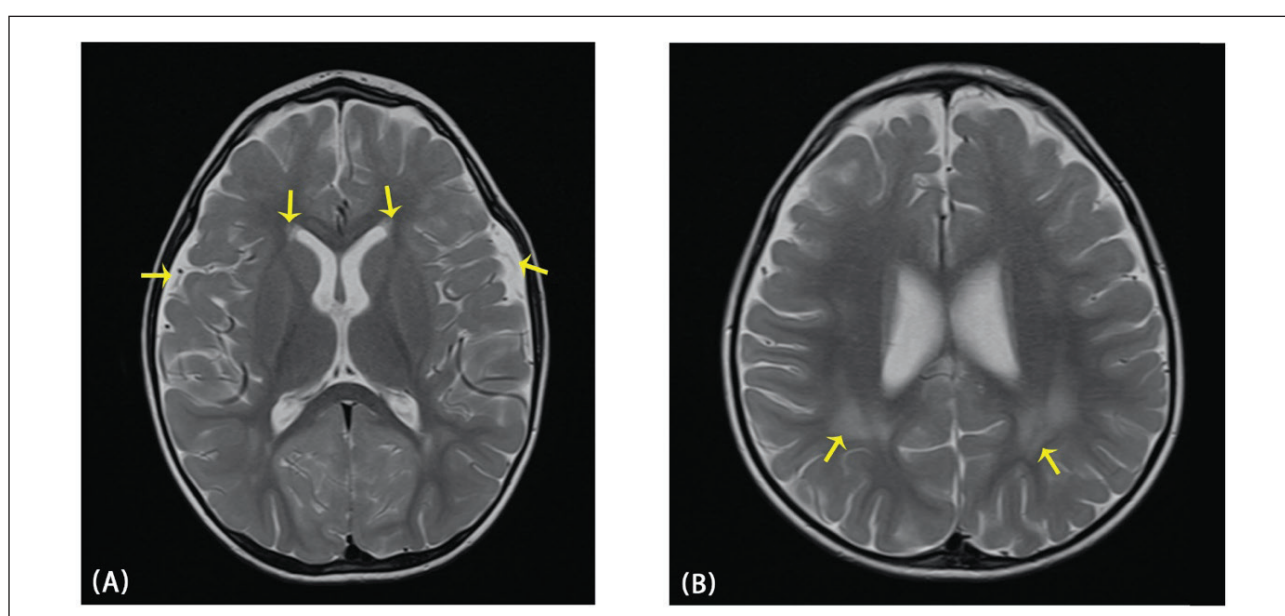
Brain MRI findings in Case 2. (A) Axial T2-weighted image showing mild diffuse cerebral atrophy with prominence of the extra-axial CSF spaces and ventricular system. (B) Axial FLAIR image showing bilateral posterior periventricular signal abnormalities.
